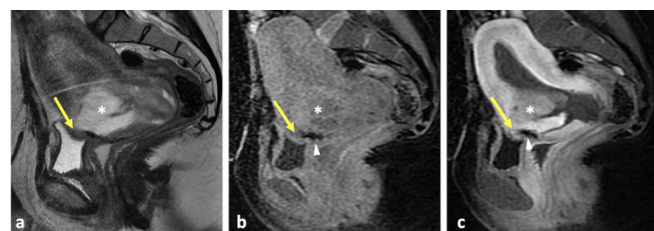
Sagittal T2-weighted (a), T1 pre-contrast (b) and T1 post-contrast (c) images of the pelvis demonstrate a bulging T2 hyperintense mass (asterisk) centered in the anterior aspect of the lower uterine segment with thinning of the overlying myometrium. The mass enhances on post-contrast images and extends toward the outer myometrium. Contour deformity of the lower uterine segment abuts the posterior bladder dome (arrows) without signal abnormality in the bladder wall. Susceptibility artifact adjacent to the mass represents postsurgical changes from prior cesarean section (arrowhead).
